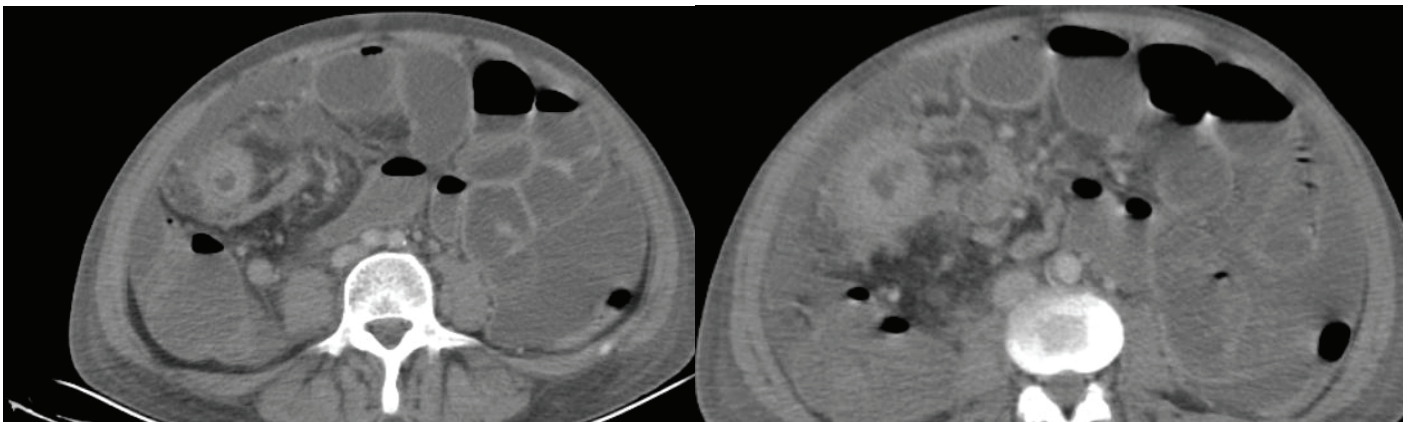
CT enterography showing intestinal stricture, abscess, vasa recta engorgement, and prestenotic dilatation in a patient with Crohn's disease. The stricture is considered inflammatory because it shows mural thickening, perienteric inflammation, and increased contrast enhancement. (From ITF Gastroenterohepatology Archive).
